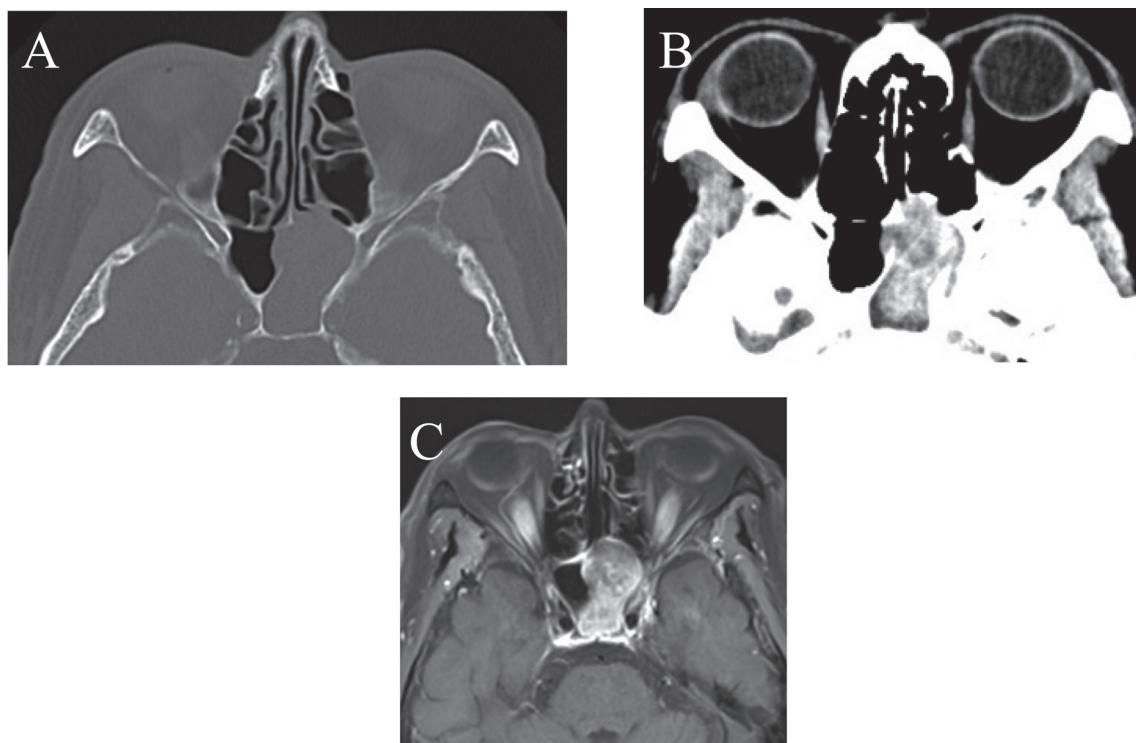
(A, B) Axial CT scan of the paranasal sinuses showed a slightly high-density, homogeneous lesion occupying the left sphenoid sinus. (C) Axial MRI showed that the tumor had high signal intensity in (C) the T1-weighted STIR image indicating strong enhancement. CT, computed tomography; MRI, magnetic resonance imaging; STIR, short T1 inversion recovery.
